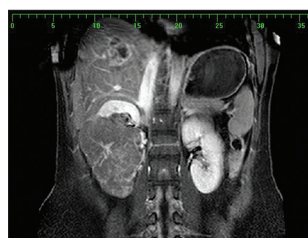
Magnetic resonance imaging - abdomen (December 2009)
